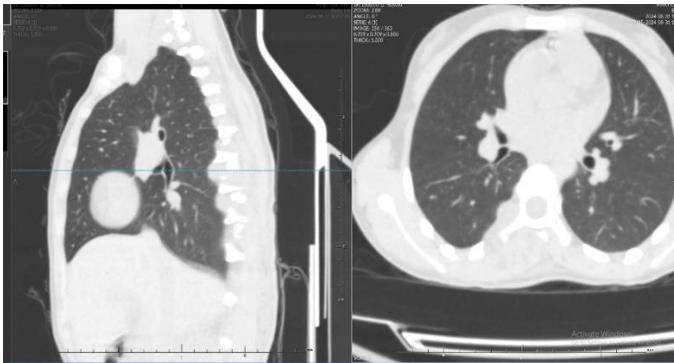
CT scan chest with IV contrast showing widening of right D7 neural foramen due to soft tissue nodule (most likely neurofibroma).
